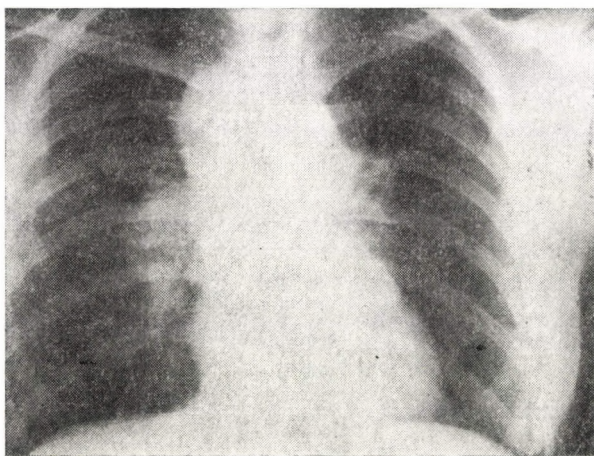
X-ray of the chest before treatment
